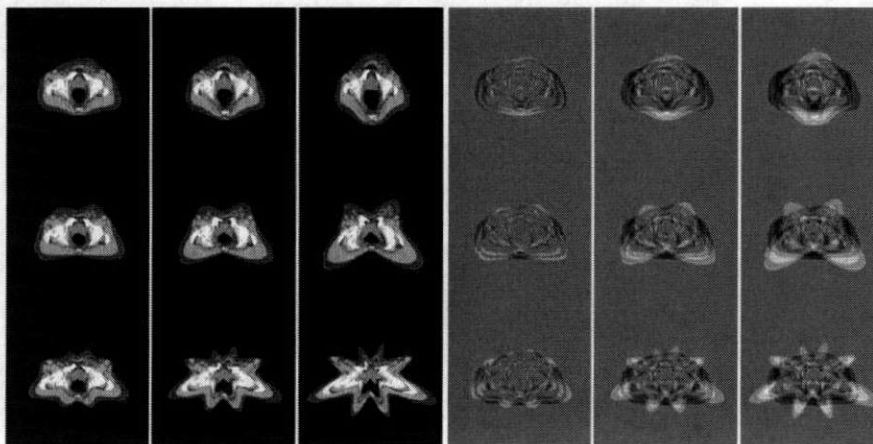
Synthetically deformed test images and their differences from the reference image. The left three columns show the test images. The right three columns show the difference images. All these test images are deformed from the same one slice CT (512×512) according to a harmonic deformation formula. From the top row to the bottom row, the harmonic parameter was $m = 2, 4, 8$ respectively. From left to right column, the harmonic parameter $b = 0.1, 0.2, 0.3$, respectively.
